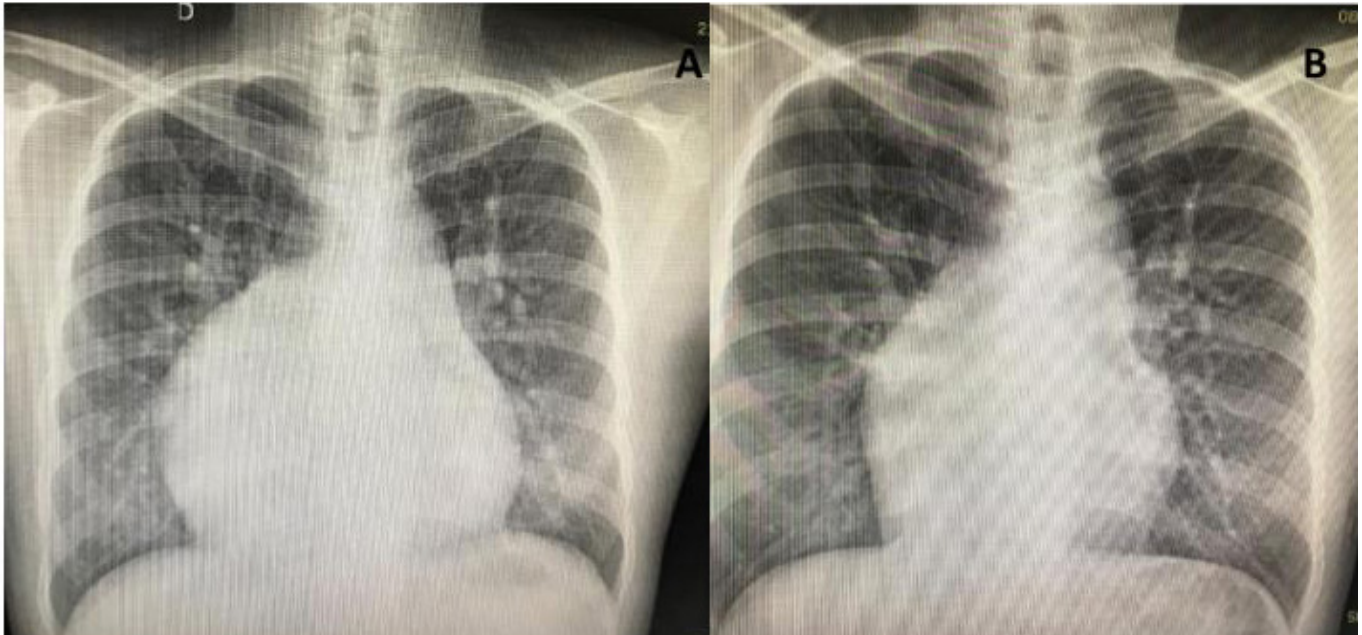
Preoperative (A) and three-year postoperative (B) chest radiographs in a currently well 31-year-old patient with congenitally corrected transposition of the great arteries and a mesocardiac positioned heart submitted to a large atrial septal defect closure plus a mechanical tricuspid valve replacement (same patient of Figure 3D).
